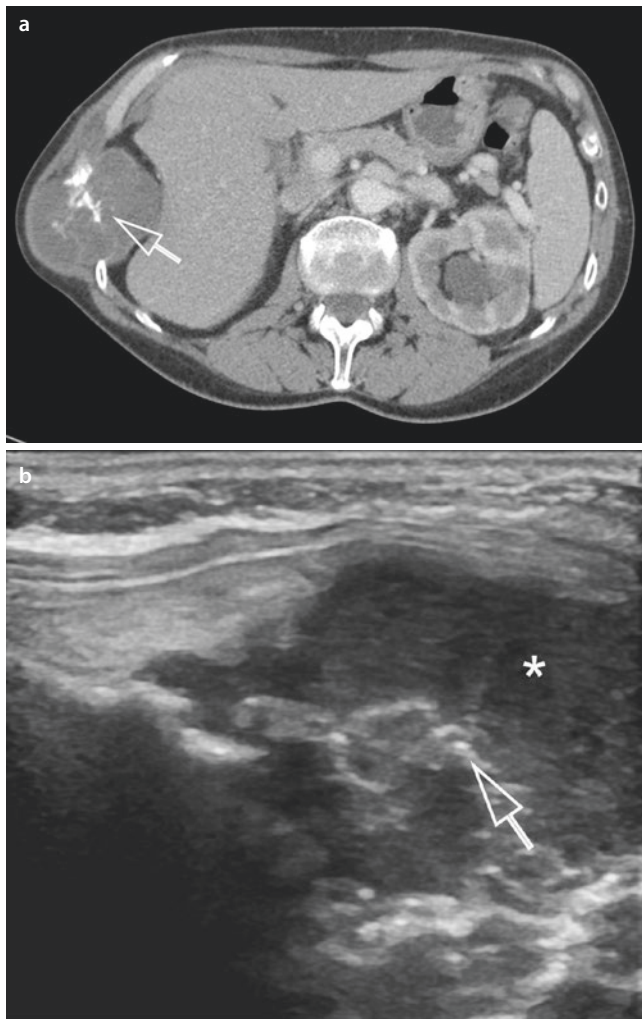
Chondrosarcoma of the chest wall. a CT reveals an extensive space-occupying lesion with dense soft tissue and chondroid calcifications (*arrow*). b Ultrasonography shows an inhomogeneous hypoechoic space-occupying lesion (*) with coarse cloddy calcifications (*arrow*). An ultrasound-guided biopsy was able to confirm the suspected chondrosarcoma
